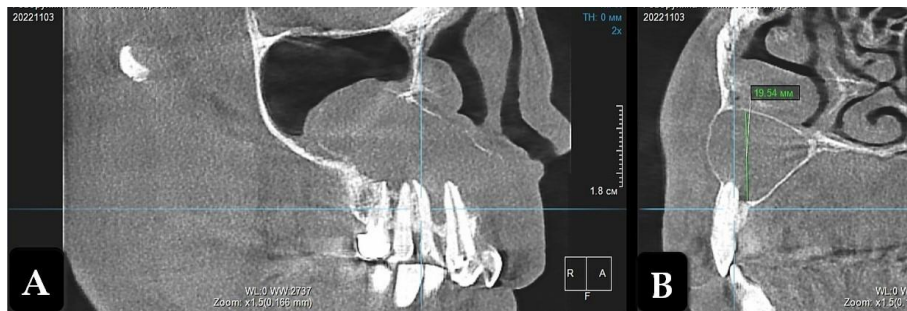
Cone-beam computed tomography. Maxillary radicular cyst before treatment (projection of tooth 12). A: Frontal projection; B: Sagittal projection.
